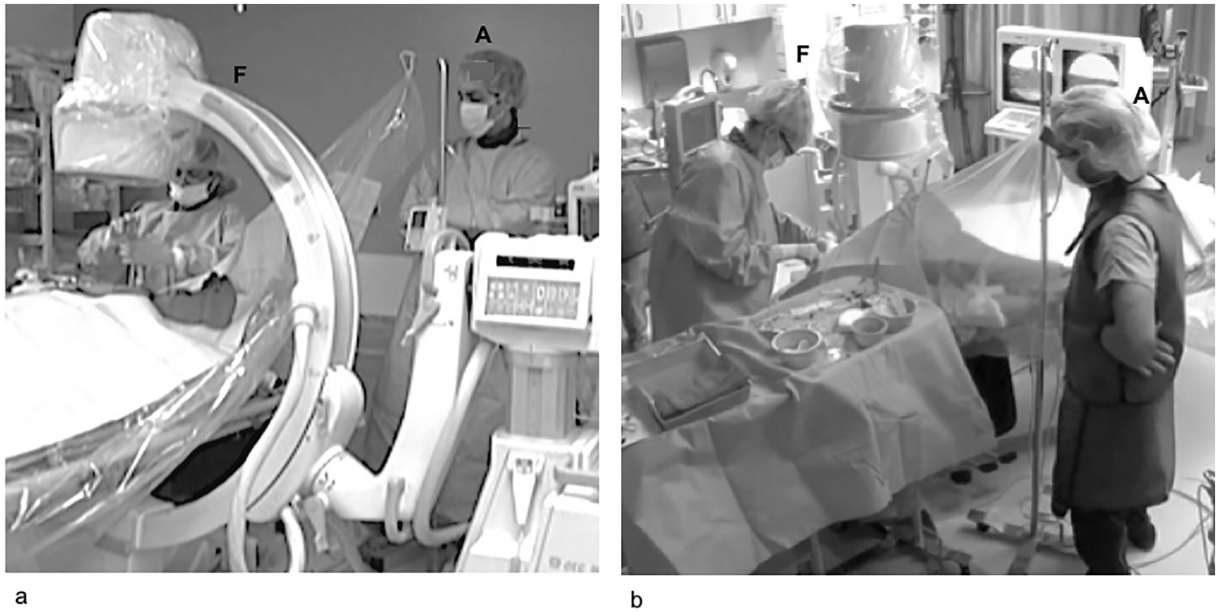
A junior Attending and a senior Attending wearing different attires while supervising a Fellow at the end of training. In (a) the junior Attending is fully scrubbed in and in sterile cloths. He stands at the head of the catheter table (right) watching the Fellow performing the procedure. In (b) the senior Attending is not in sterile cloth but only wearing the lead apron for protection against X-ray. He stands on the other side of the catheter table (right) to hold the patient's hand while watching the Fellow performing the procedure across from him.
